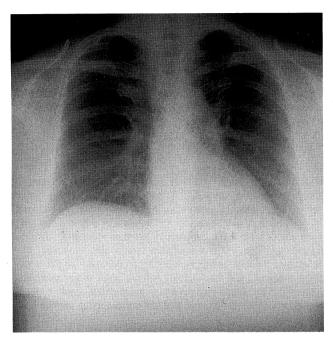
A chest x-ray film on admission revealing ground-glass opacities in both lung fields.
